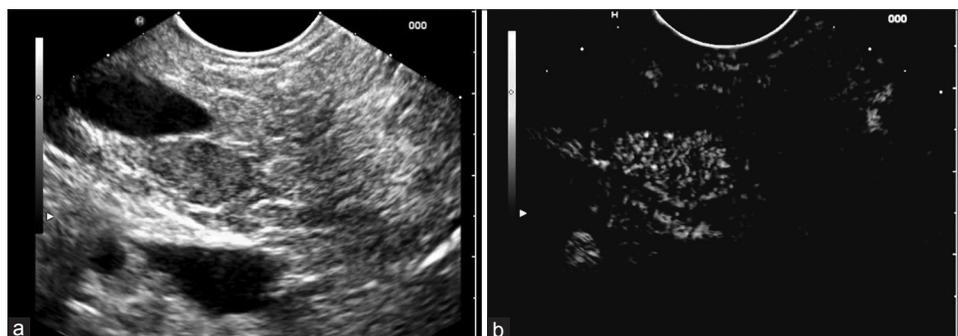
Insulinoma in the pancreatic head using B-mode (a) and contrast-enhanced endoscopic ultrasound with early hyperenhancement in comparison to the surrounding pancreatic parenchyma (b). Portal vein and inferior vena cava do not show enhancement during this very early contrast phase
